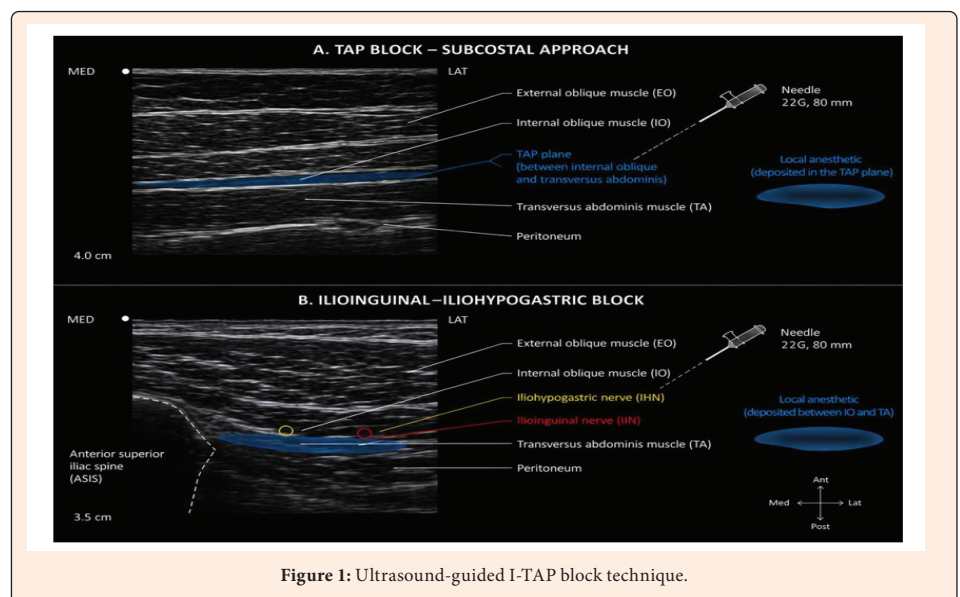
Ultrasound-guided I-TAP block technique.
